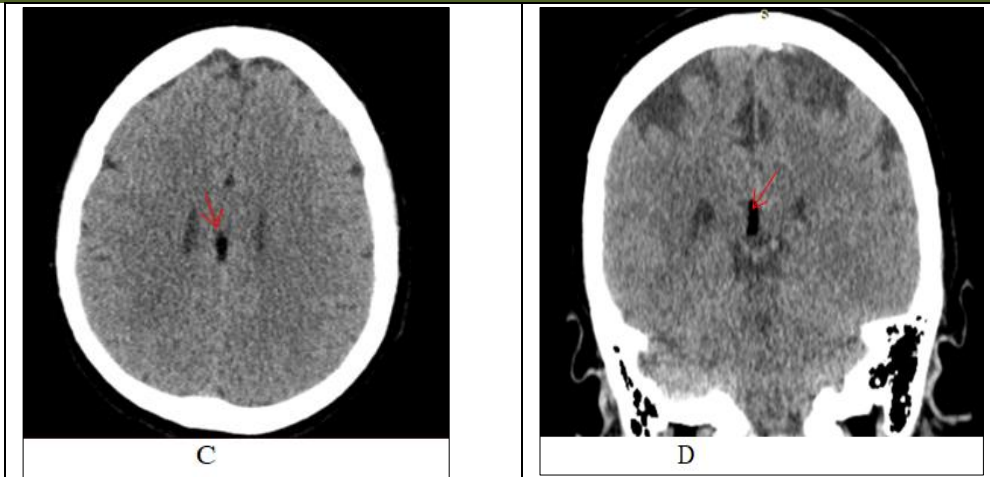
Sagittal, axial and frontal reconstructions CT. Thin fat density structure that lies superior to the corpus callosum, and extends from the anterior aspect of the body of the corpus callosum posteriorly, wrapping around the splenium of the corpus callosum (red arrow)
